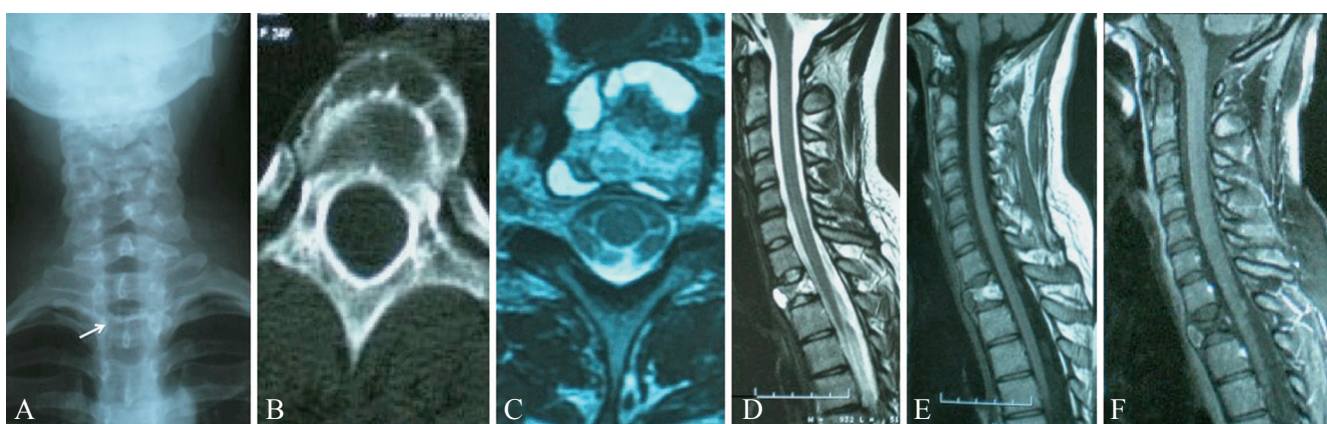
Preoperative radiological studies: A) preoperative XR imaging; a subtle irregularity is noted on the upper lamina of T1; B) axial CT image of the lesion. C-F) Preoperative MRI study of the patient: C) axial T2W MRI; in comparison with B, the lytic anterior aspect of the vertebra on CT seems to have a hyperintense fluid content on T2W MR images; D) sagittal T2W MRI; E) sagittal T1W MRI; F) sagittal T1W MRI shows no contrast enhancement of the lesion after gadolinium injection.
